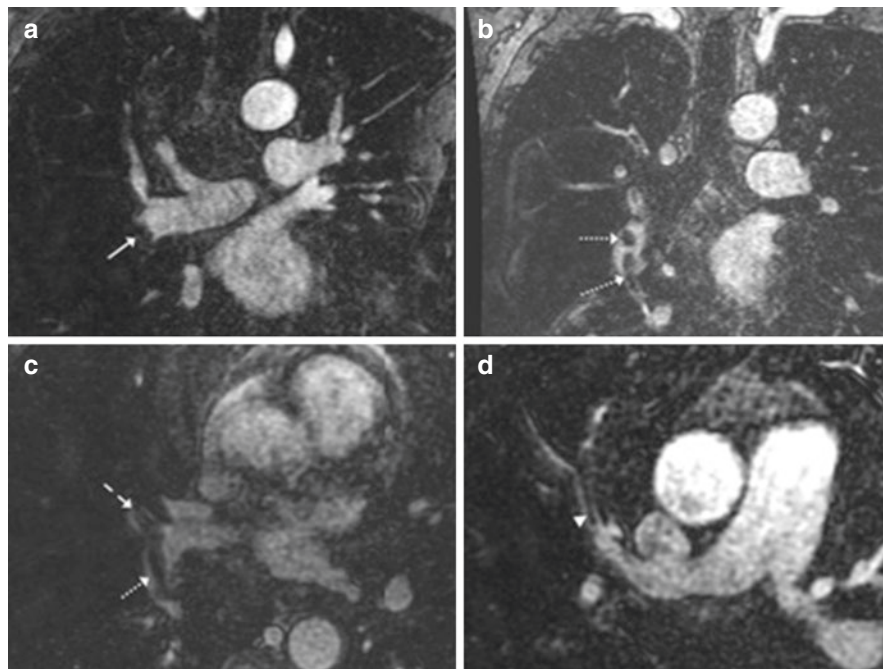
Low-signal-intensity filling defects (arrows and arrowheads) are the most common appearance of pulmonary embolism on MRA. In these four patients with PE identified on MRA, filling defects are present in (a) the right lower lobe (arrow); (b) the right middle lobe (dashed arrows); (c) right middle (dashed arrow) and lower (dotted arrow) lobes; and (d) anterior right upper lobe (arrowhead). (We sincerely thank Dr. Christopher J. Francois, Dr. Donald Benson, Dr. Mark Schiebler, Dr. Scott Nagle for the permission to use their published MRI images [5])
